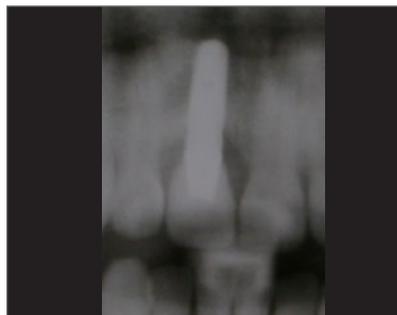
Radiograph showing vertical bony defects indicating progressive peri-implant bone resorption at T1.
